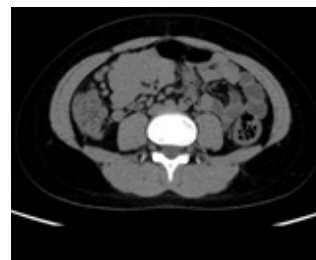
Axial abdominal CT scan.
